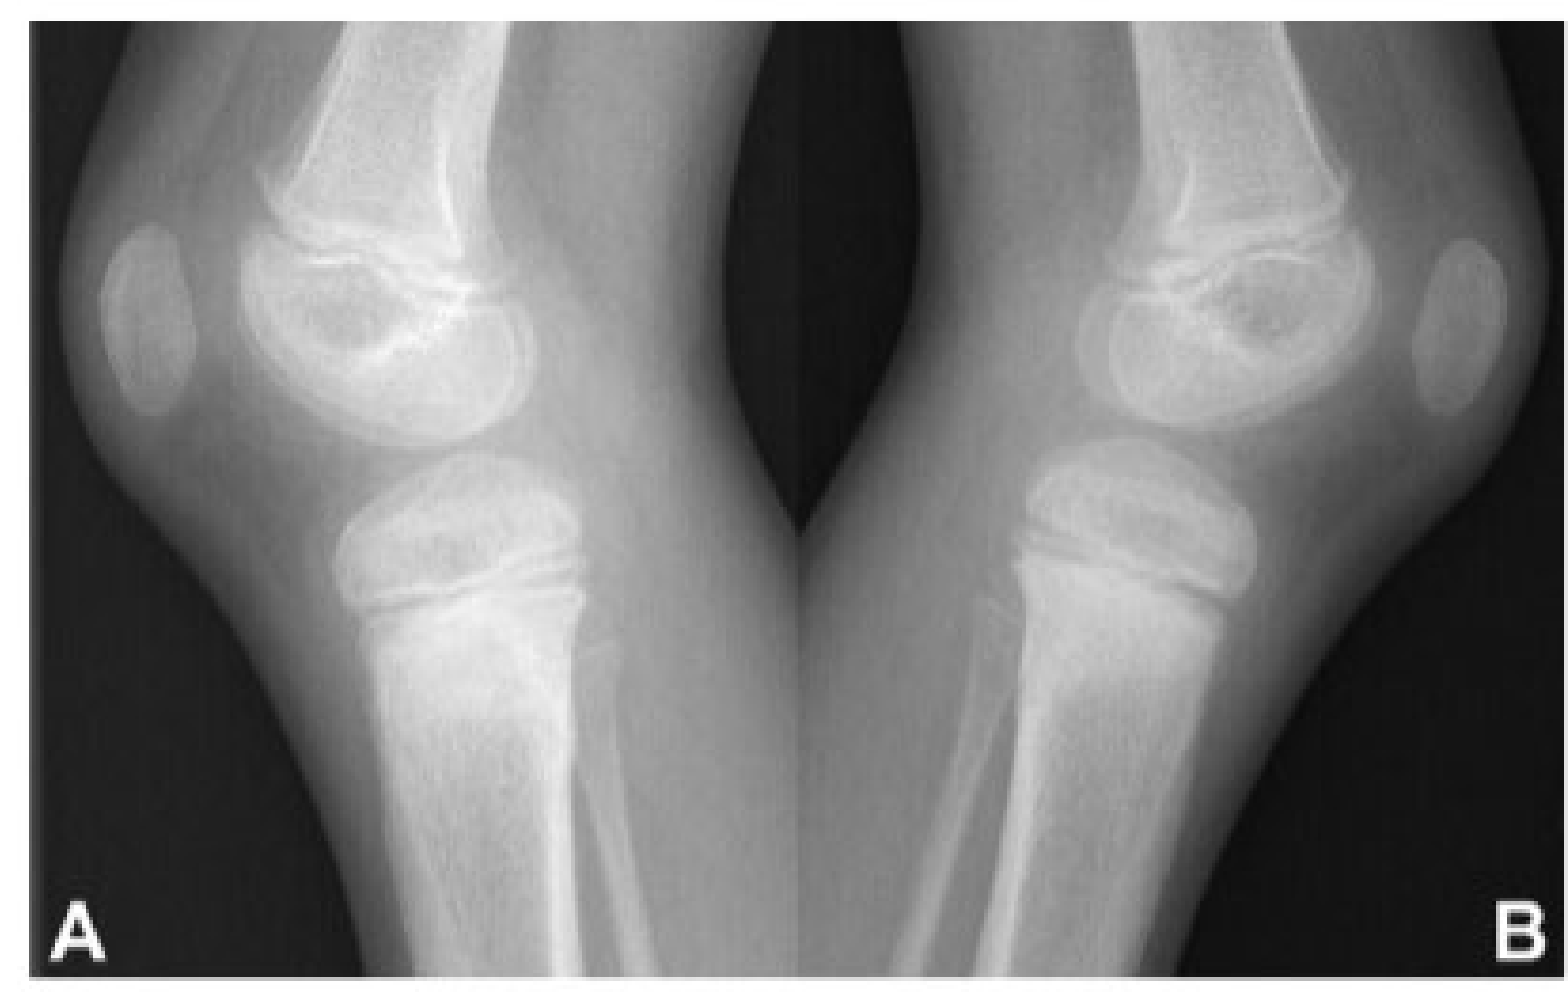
Lateral radiographs of the right (A) and the left (B) knees at 5 weeks’ follow-up show linear sclerosis in both proximal metaphyses, from anterior to posterior, without clearly visible residual fracture lines.
